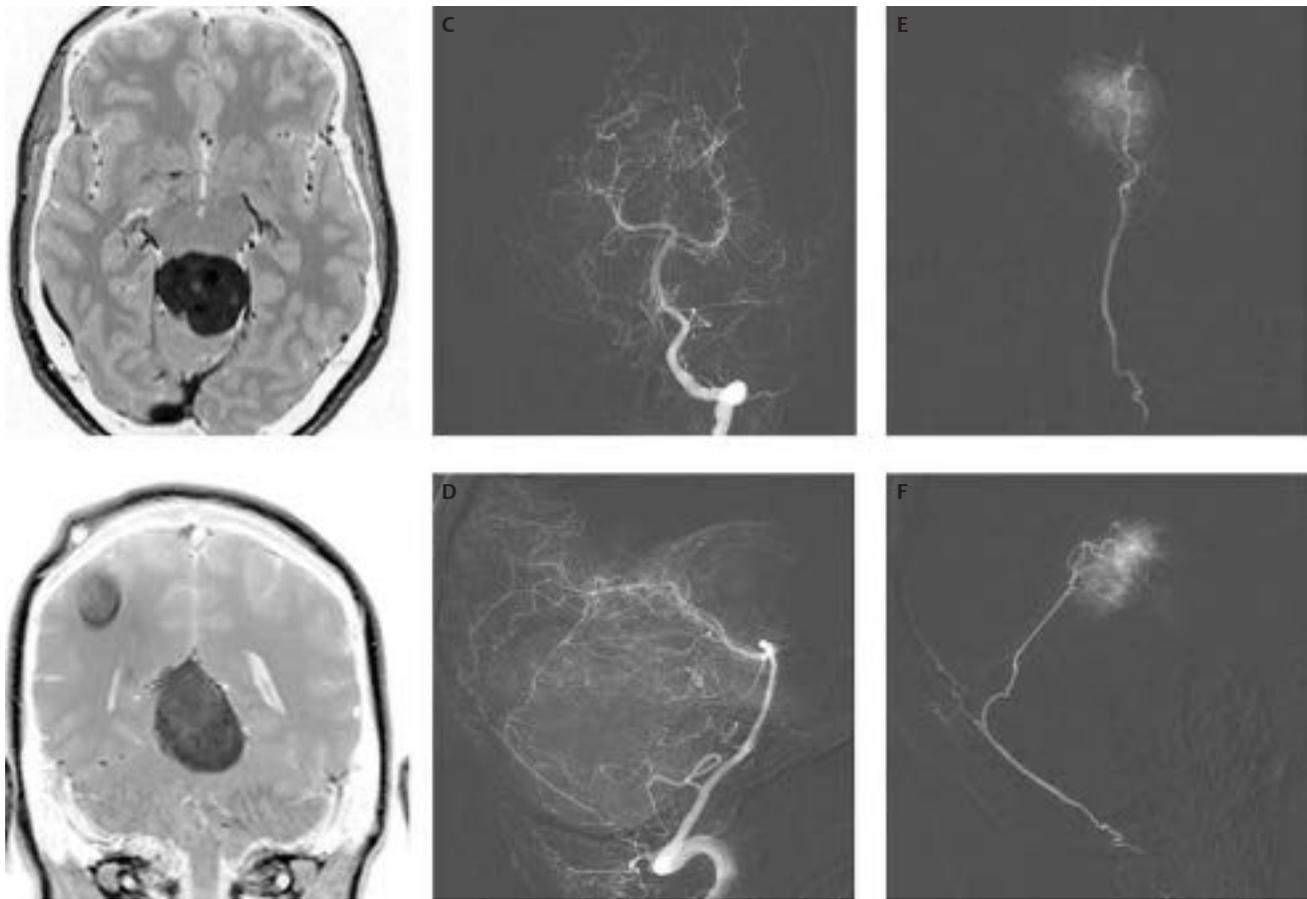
Midline tentorial meningioma. (A) Axial and (B) coronal magnetic resonance images. Artifact is seen in the right parietal lobe on the coronal image secondary to the presence of a ventriculooperitoneal shunt. (C) Anteroposterior (AP) and (D) lateral left vertebral artery angiograms demonstrating a tumor blush in the midline tentorial region being supplied by the posterior meningeal branch of the extracranial vertebral artery. (E) AP and (F) lateral superselective angiograms of the posterior meningeal branch of the left vertebral artery demonstrating the dural vascular supply to this deep midline tumor.
